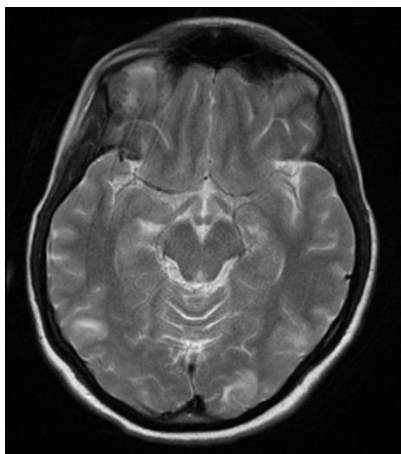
Multiple cortico-subcortical areas of T2-weighted hyperintense signal involving the occipital lobes bilaterally in axial plane
